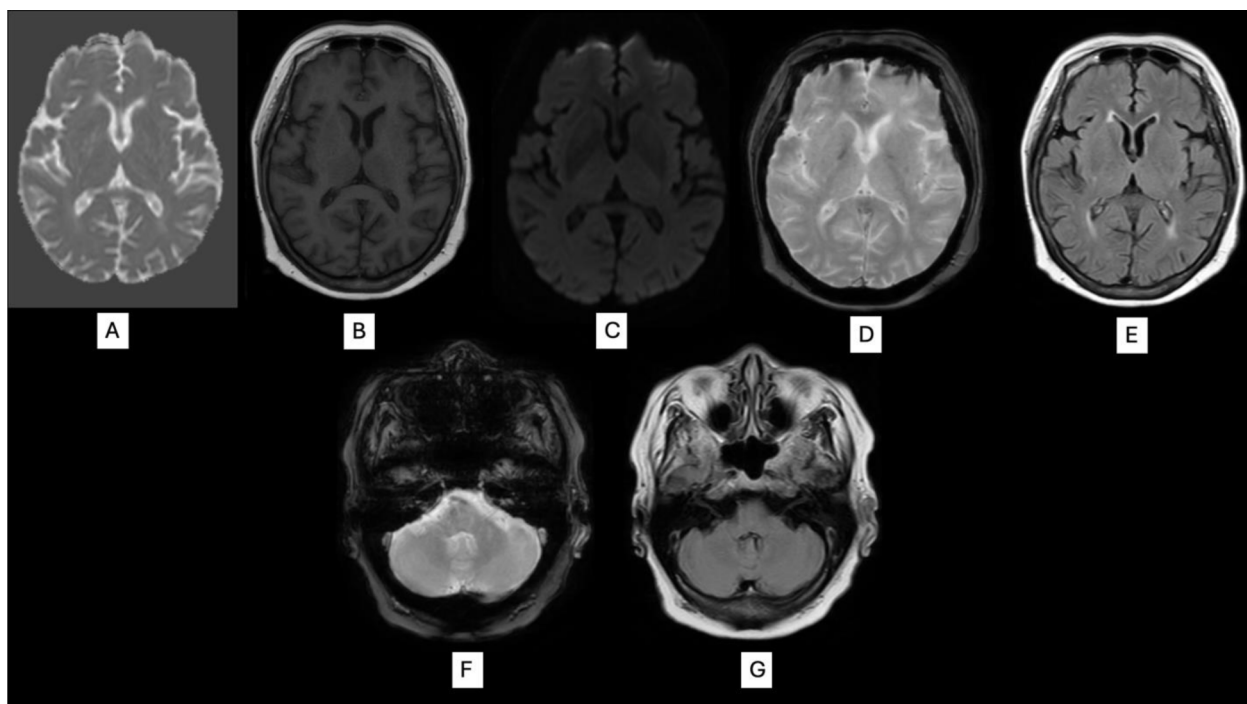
Plain cranial MRI (A-E: DWI, ADC, T1 and T2 sequences of the cerebrum, F-G: T2 sequences of the cerebellum showed no evidence of acute infarction, hemorrhages, mass lesions, or infection.
